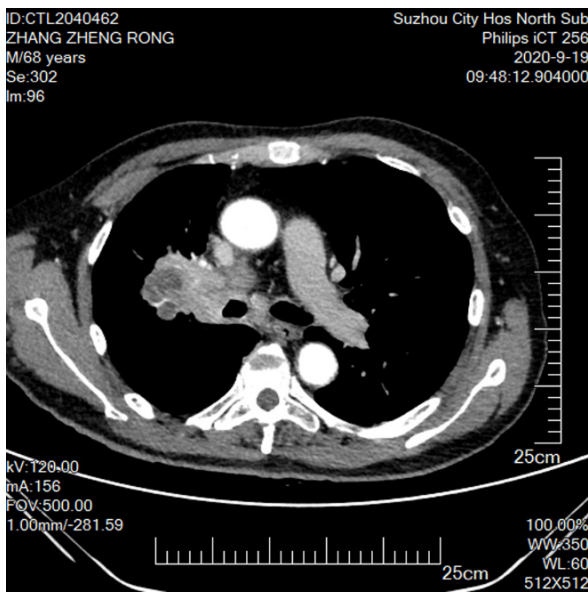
45 were pleural indentation signs which were indicated by CT.
